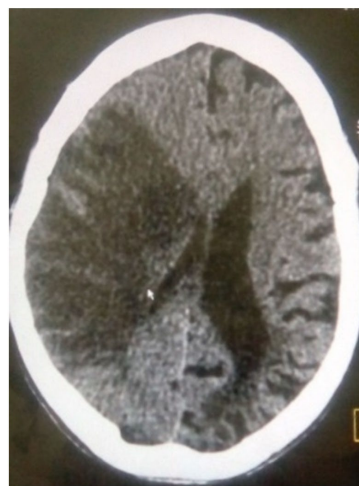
An axial section of the brain CT showing a left Fronto-temporo-parietal Hypodensity in the shape of a crescent moon, indicating a chronic subdural hematoma.
